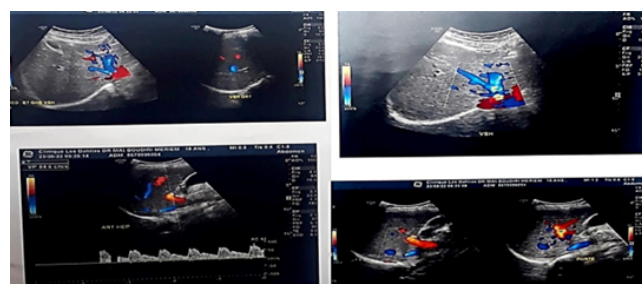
Abdominal Doppler repermeabilization of the hepatic veins.
